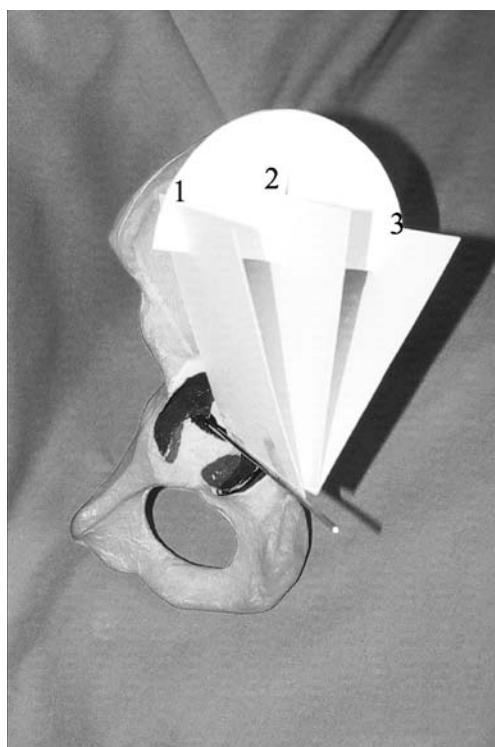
Sonographic images of different sectional planes through the acetabulum. The rotational axis is through the lower limb of the os ilium. 1, Anterior plane; 2, standard (middle) plane; 3, posterior plane
